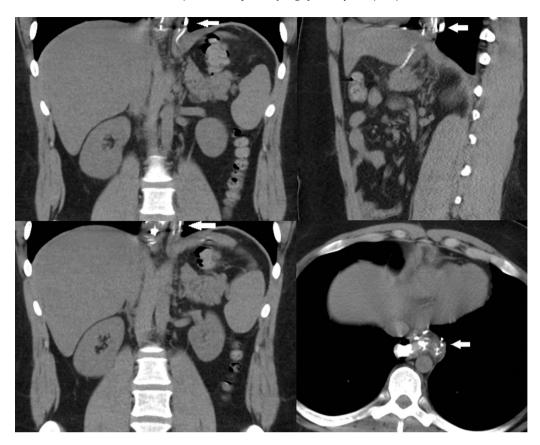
Abdominal CT scan showing possible intra-thoracic staple line (white arrow).
